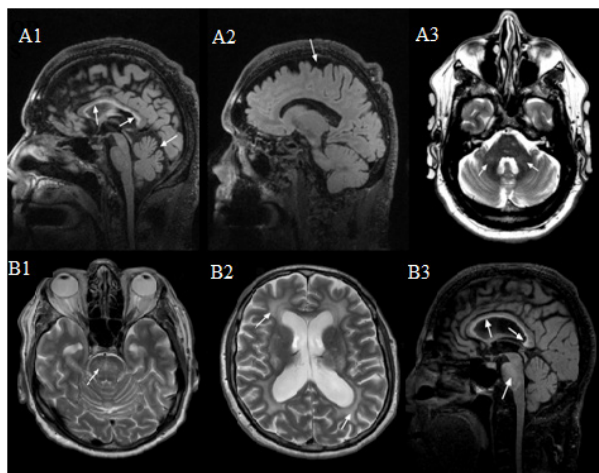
MRI features of FXTAS. (A1) Moderately thin truncus of the corpus callosum with severe increased signal intensity in both the truncus and the splenium, and moderate cerebellar and cerebral (A2) volume loss. (A3) Mild white matter changes in the middle cerebellar peduncles (MCPs). (B1) Severe increased T2 signal intensity in the pons (can also be seen in B3). (B2) Severe diffuse increased T2 signal intensity in the deep white matter of the cerebrum, as well as periventricular. (B3) Moderately thin truncus of the corpus callosum with severe increased T2 signal intensity in both the truncus and the splenium.
